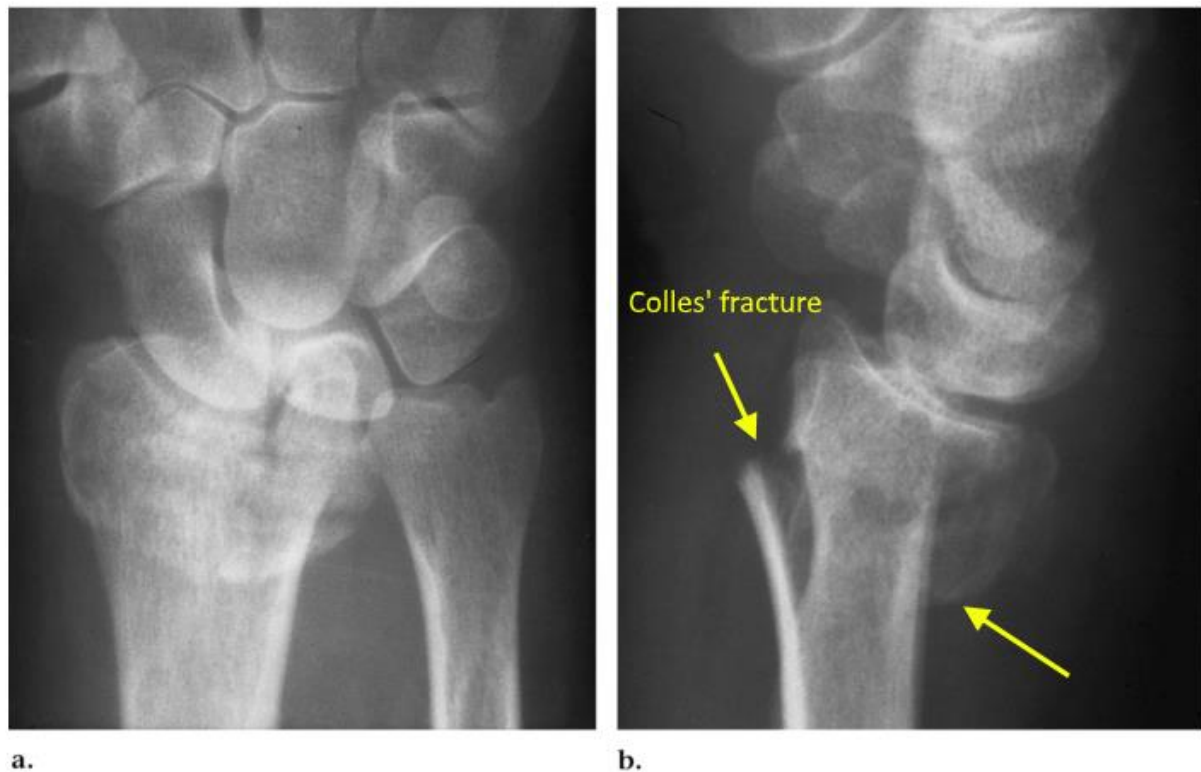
(a) Posterior-anterior radiograph of the left wrist demonstrating a distal radial fracture. (b) Lateral radiograph of the same wrist demonstrates a distal radius fracture with the distal fracture fragments displaced and angled dorsally relative to the proximal fracture fragment (Image from Goldfarb et.al., [24]).
